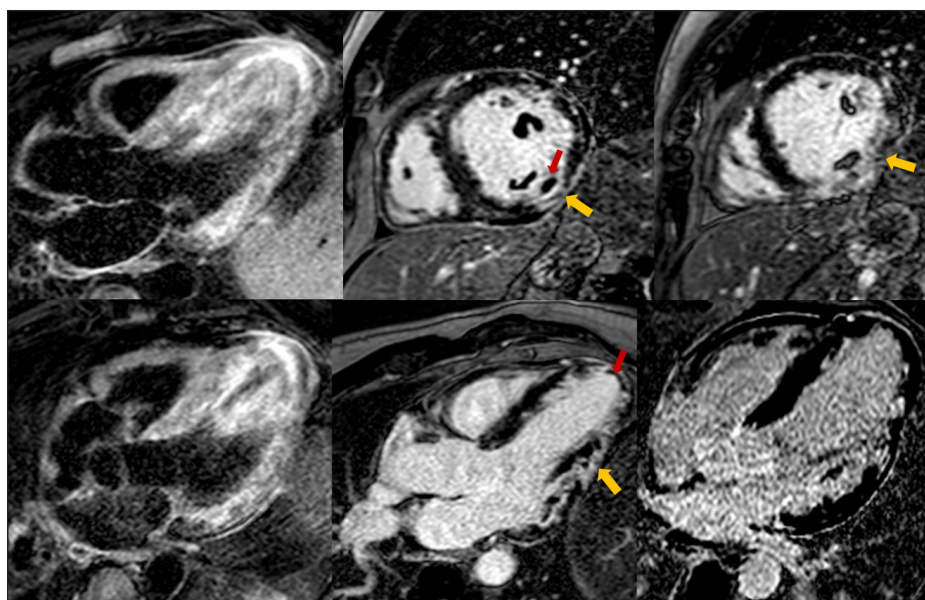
Cardiac MRI showing recent inferior and inferolateral infarction (yellow arrows) and intracavitary thrombi (red arrows).
